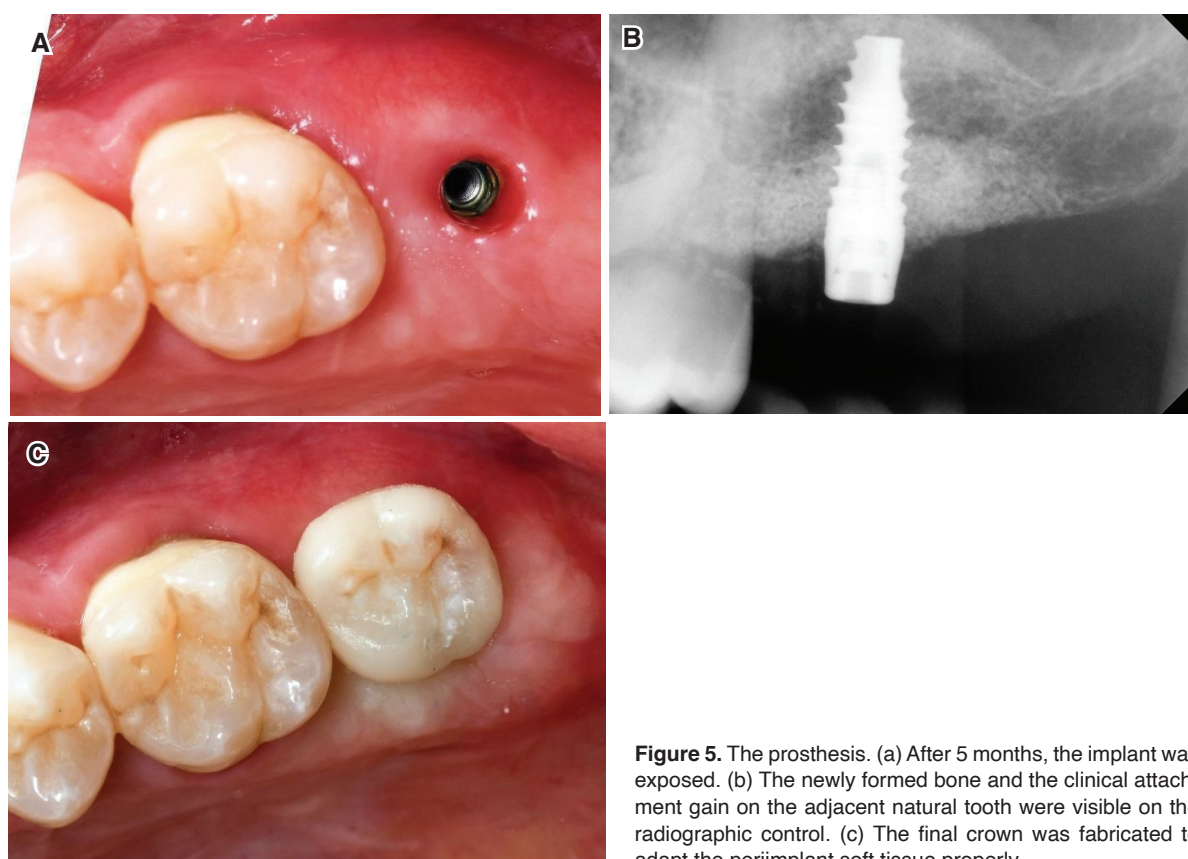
The prosthesis. (a) After 5 months, the implant was exposed. (b) The newly formed bone and the clinical attachment gain on the adjacent natural tooth were visible on the radiographic control. (c) The final crown was fabricated to adapt the periimplant soft tissue properly.
